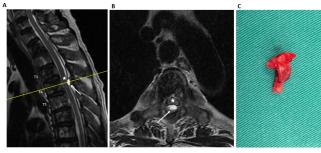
(a) Sagittal and (b) cross section of T2 weighted MRI images showing a round hyperintense extramedullary extradural cystic lesion (arrow) compressing onto the posterior column of the spinal cord (star) at the level of T4. (c) Post excision photo showed the cyst from ligamentum flavum at level of T4.
